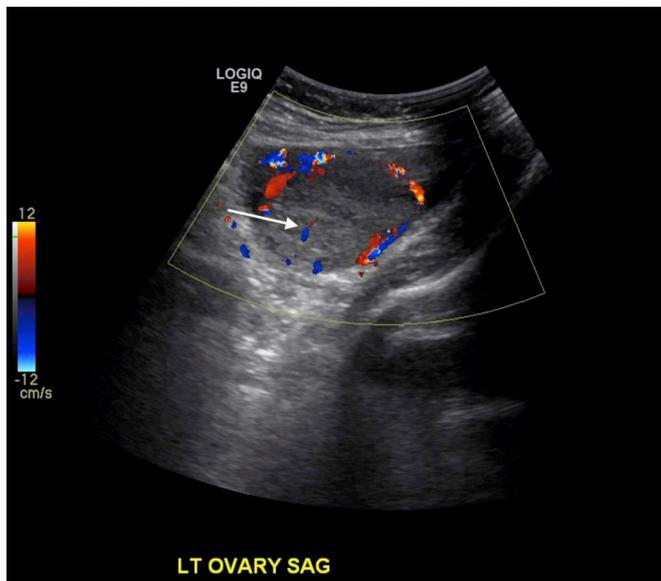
Pelvic ultrasound with sagittal image of the left ovary demonstrates a predominantly solid isoechoic mass with mild posterior acoustic enhancement and minimal internal color Doppler flow (arrow).
